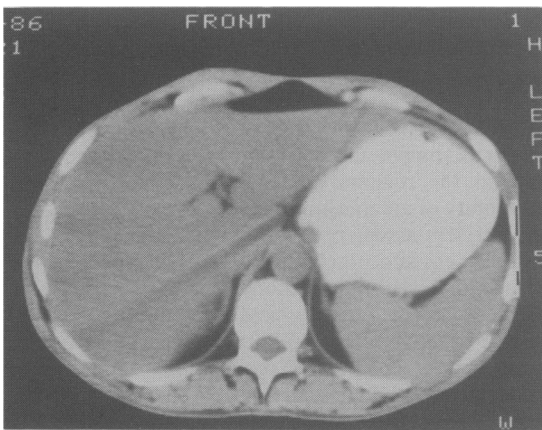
CT scan 6 months later, showing reduction in size and fat content of the liver.
